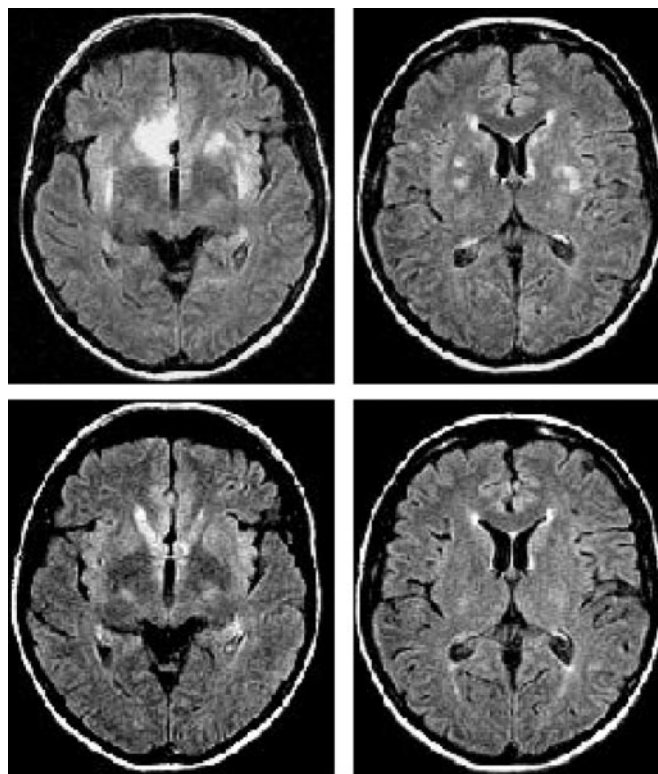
Acute MRI (upper row) disclosed hyperintensities in the basal ganglia, the frontoorbital cortex, and the adjacent white matter appearing in the fluid-attenuated inversion recovery images, but without contrast or changes in diffusion-weighted imaging, which argues for vasogenic edema without cytotoxicity. MRI 3 weeks later (bottom row) shows that the lesions disappeared. A small structure evoking carcinomatous meningitis remained unchanged (not shown).
